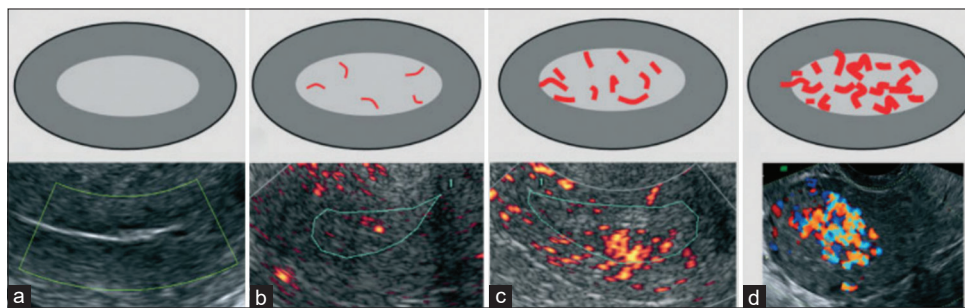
Color score of the endometrium on Doppler assessment based on the International Endometrial Tumor Analysis consensus statement^[6] (a) absent flow (b) minimal flow (c) moderate flow (d) abundant flow
